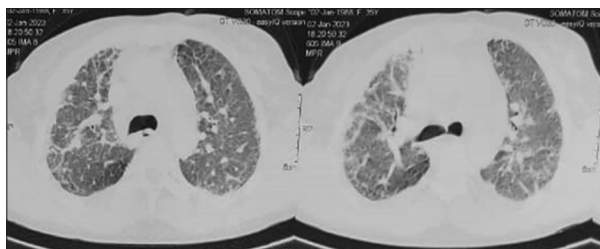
High-resolution computed tomography chest showing diffuse interlobular septal thickening and reticular opacities in bilateral parenchyma with few areas of ground-glassing (Left > Right) and associated fibrotic changes in the right upper and middle lobe. Features suggestive of fibrotic non-specific interstitial pneumonia-Interstitial lung disease
